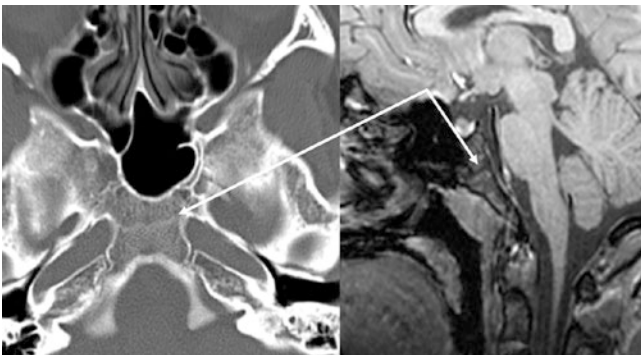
An 18 year old with a sclerotic SOS (*arrow*) that is recently and nearly completely fused, as shown on axial NECT (*left*) and on a sagittal T1-weighted MRI (*right*) obtained at 3 T
